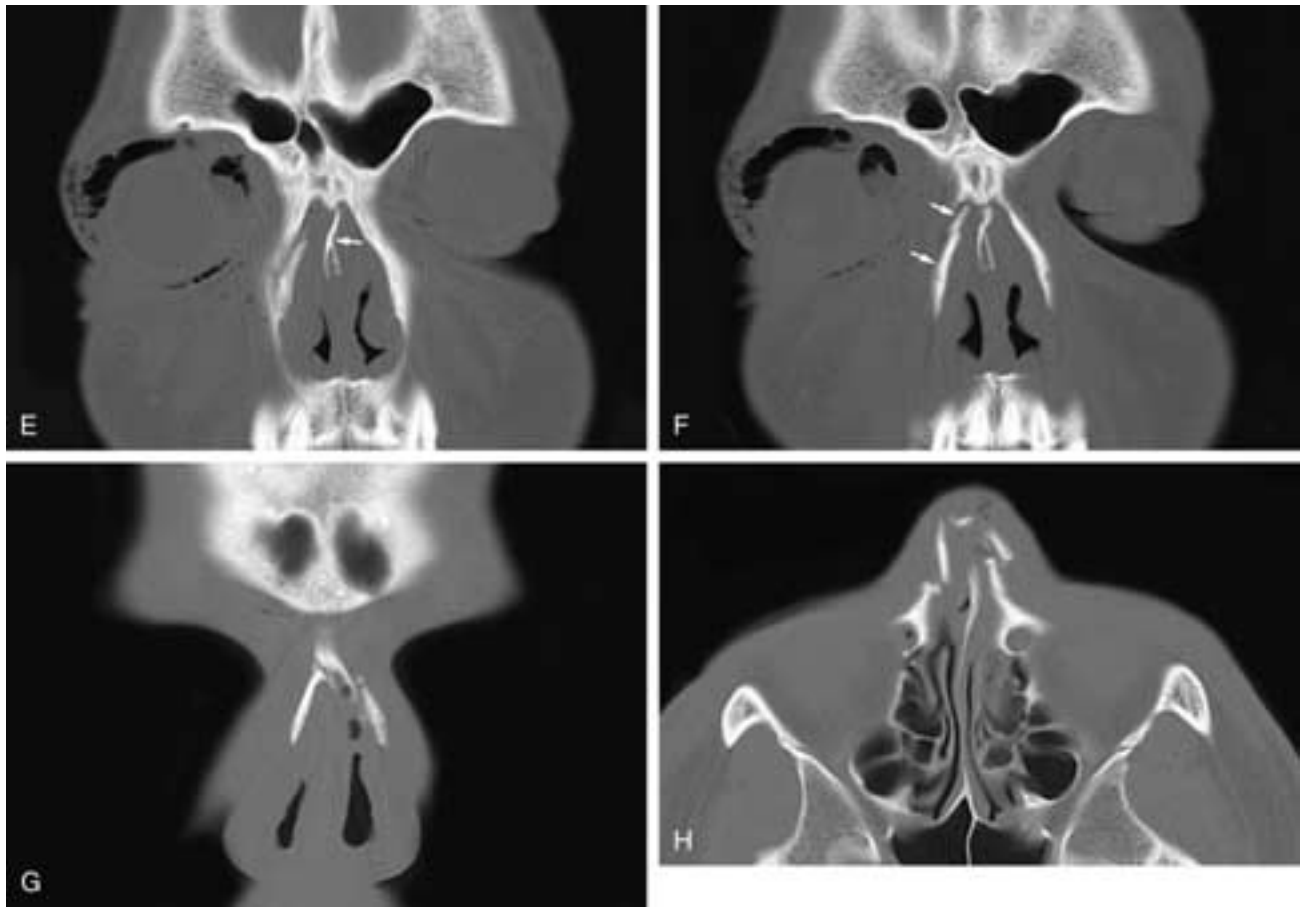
Continued.* Coronal CT scans (E, F) on a different patient show medially displaced comminuted fractures of the right nasal bone (*arrow* in E) and a displaced fracture of the anterior bony nasal septum (*arrows* in F). There is also orbital emphysema on the right side from an ethmoid fracture. Coronal (G) and axial (H) CT scans on yet another patient show comminuted fractures of the nasal bones and the right frontal process of the maxilla.
